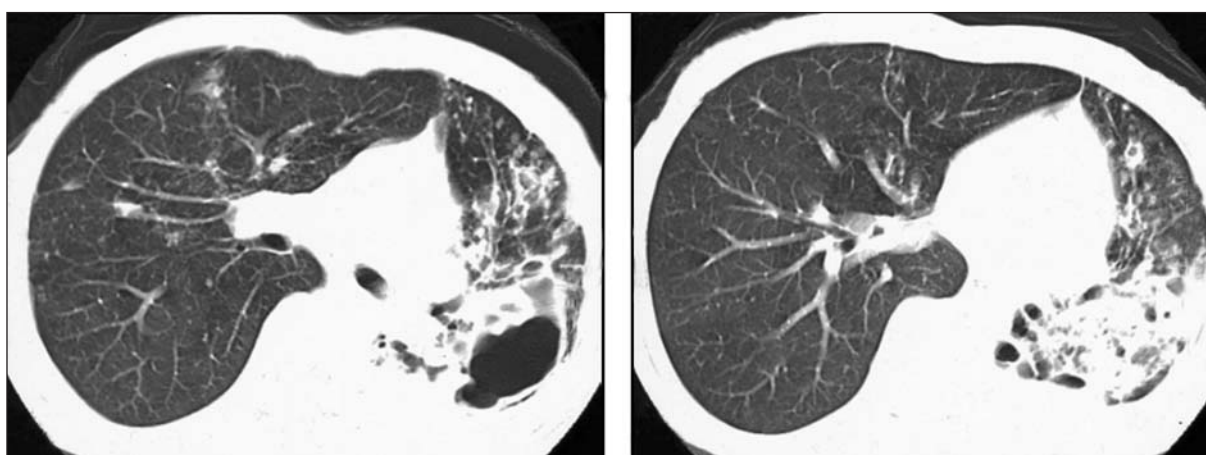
High resolution CT at the admission revealed cystic and varicose bronchiectasis, some of them were filled with mucus and tree in bud, multiple micro nodular infiltrates on both lung fields. Cavitations and consolidation were seen in the lingula.
